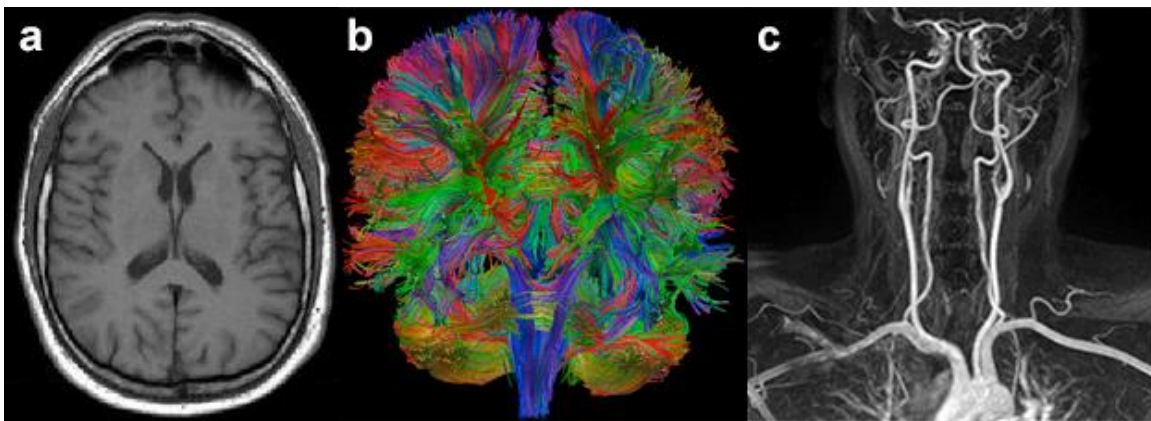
(a) T1-weighted MR image of the brain; taken from [232]. (b) Diffusion Tensor Imaging; taken from [233]. (c) Normal neck magnetic resonance angiography; taken from [234]
